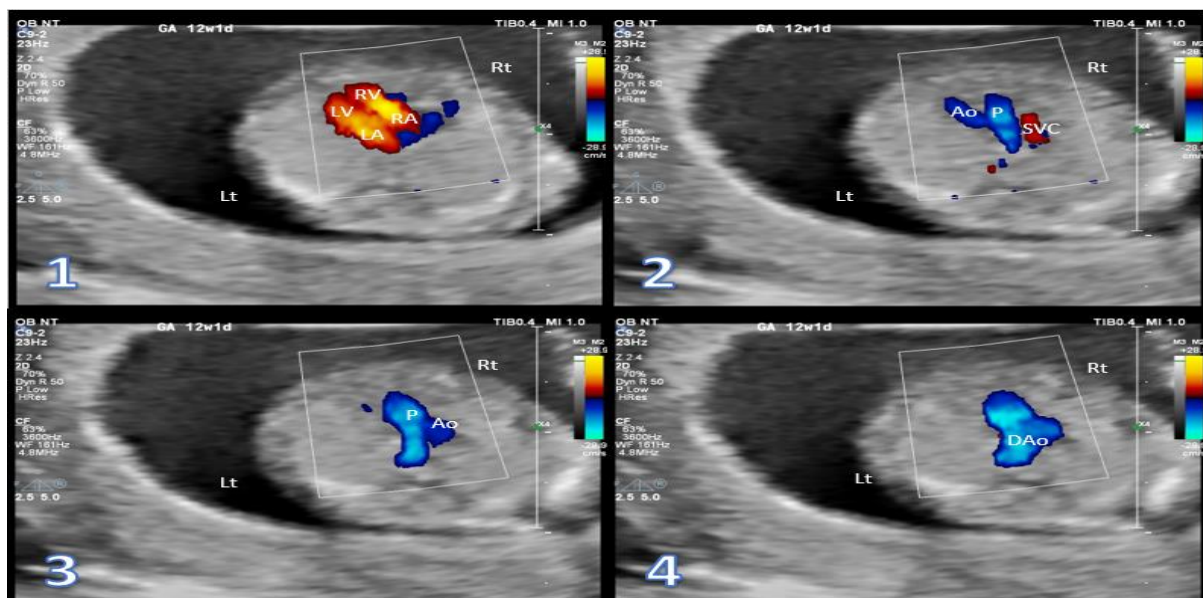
First trimester (12 weeks + 1day gestational age) cardiac sweep in a normal fetus. (1) Four-chamber view Doppler mode: parallel flows from both atria to both ventricles; (2) 3-vessel view; (3) Crossing of the great vessels. (4) Ductus arteriosus. Lt, left; Rt, right; LV, left ventricle; RV, right ventricle; LA, left atrium; RA, right atrium; Ao, aorta; P, Pulmonary trunk; DAo, ductus arteriosus; SVC, superior vena cava.
